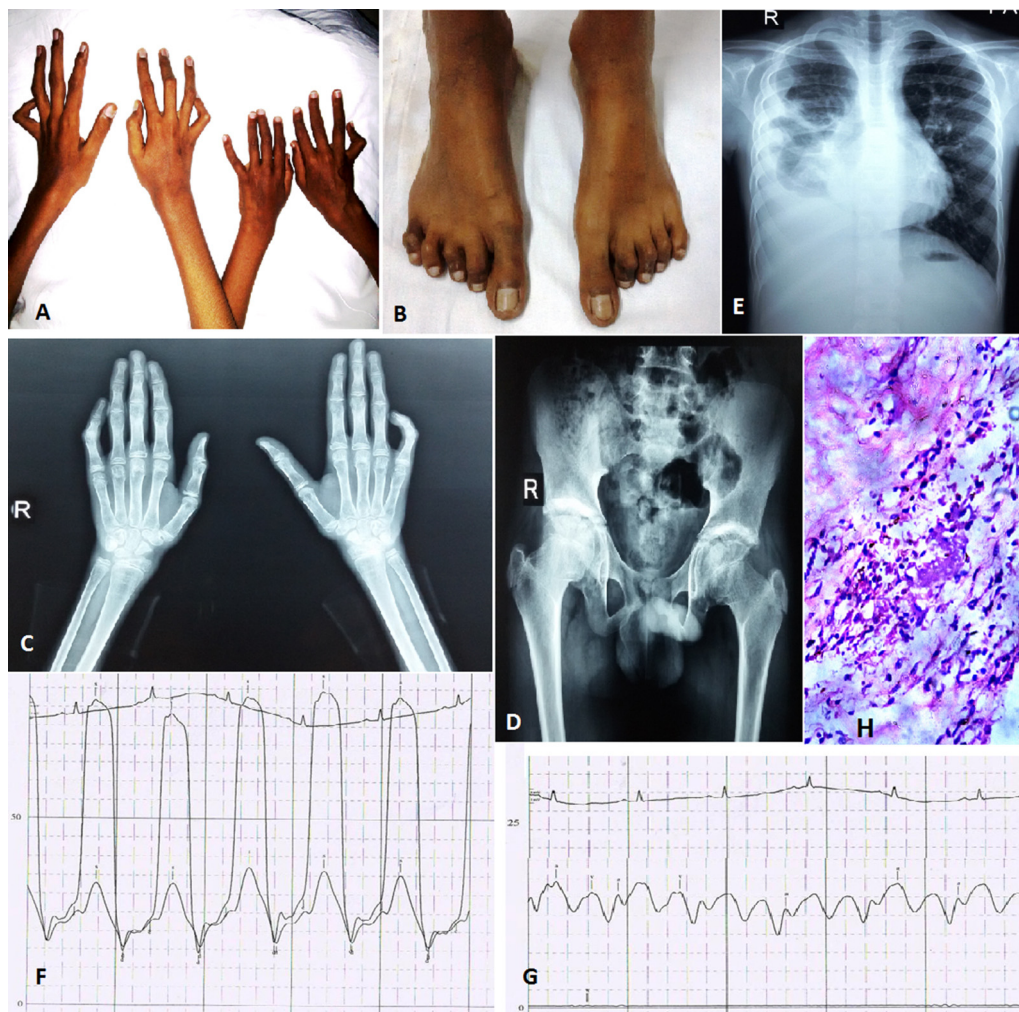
Photograph demonstrating (A) bilateral camptodactyly in upper limbs of both the brothers; (B) flexion deformity in toes. Radiographs demonstrating (C) bilateral fifth finger camptodactyly; (D) bilateral hip joint showing short femur neck, flattened acetabulae, and nonerosive arthropathy without periarticular osteopenia and (E) chest radiograph showing right pleural effusion. Pressure tracing showing (F) ventricular interdependence in simultaneous right and left ventricular tracing and (G) prominent x and y descent in jugular venous pressure tracing. Microphotograph of knee synovial biopsy under high magnification (H) demonstrating noninflammatory arthritis and synovial hyperplasia.
